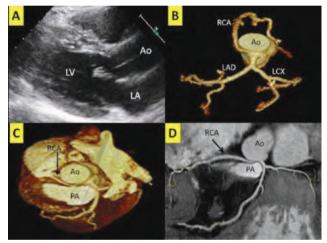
(A) Transthoracic echocardiography (Parasternal long axis view) showed non-obstructive hypertrophic cardiomyopathy. (B) MCTCA volume rendering wiew showed RCA from left sinus valsalva. (C) MCTCA showed RCA from left sinus valsalva and it had an interarterial course (between the pulmonary trunk and aorta) (arrow). (D) MCTCA showed anomalous origin and interarterial course of RCA. Ao: Aorta, LV: Left Ventricle, LA: Left Atrium, PA: Pulmonary Artery, RCA: Right Coronary Artery, LAD: Left Descending Artery, LCX: Left Circumflex Artery, MCTCA: Multidetector computed tomography coronary anjiography.
